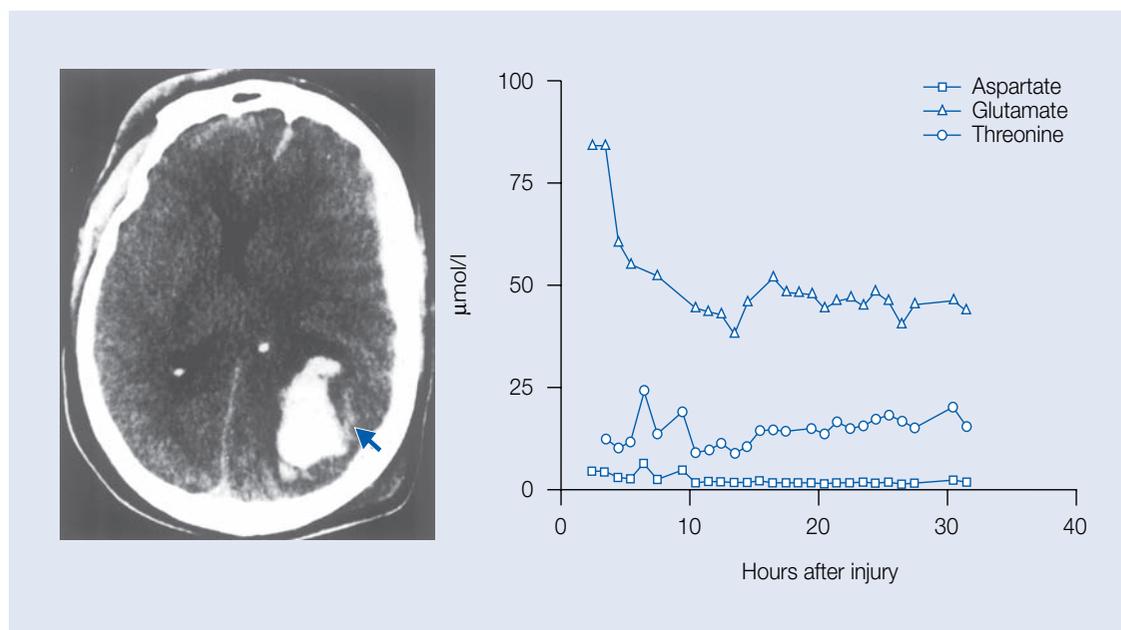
Graph, again from the work of Bullock, showing typical 'decline and stable baseline' pattern of very high excitatory amino acids (EAAs) in a patient with focal contusions at the probe placement site. The patient made a good recovery. Left: Preoperative computed tomographic scan showing a right hemisphere subdural hematoma and focal hemorrhagic contusion. The microdialysis probe was placed in position (arrow) after the hemorrhagic contusion was evacuated. Right: Graph displaying the pattern of dialysate EAA and structural amino acid changes over 30 hours of monitoring. Note that glutamate was approximately 25 times higher than the normal value of $<2 \mu\text{mol/L}$. Figures 4-6 and 4-7 demonstrate the marked contrast in the excitotoxic response between diffuse injury and focal contusion, respectively
